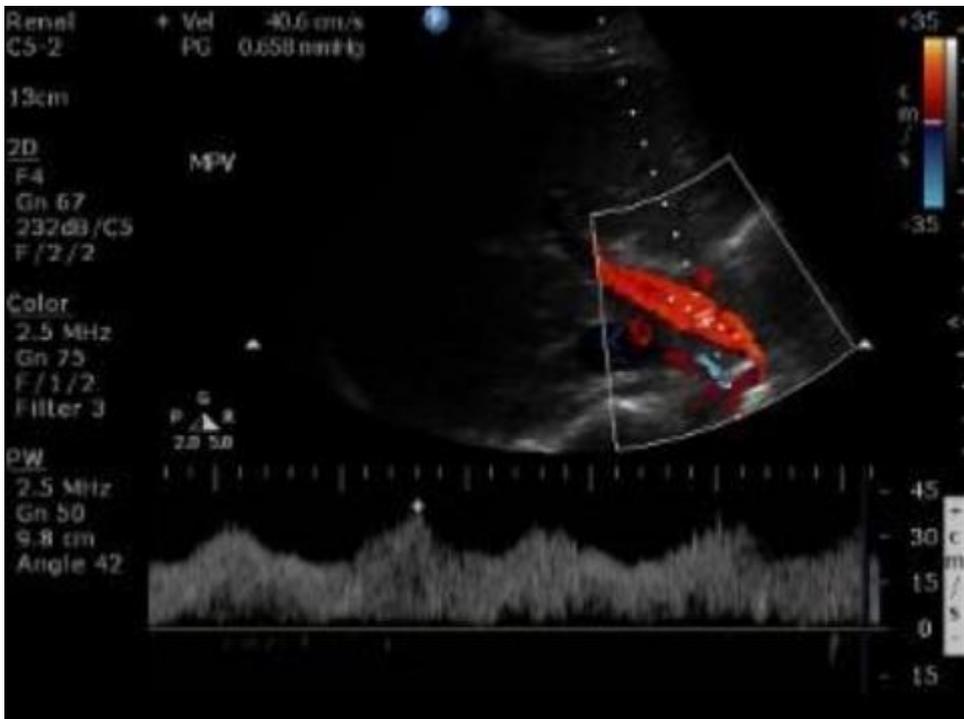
Correct angle for Doppler interrogation of the portal vein.
